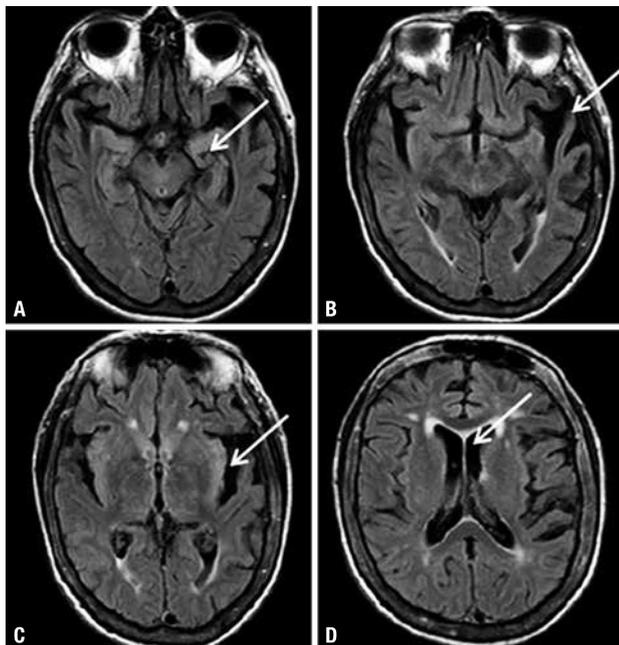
Axial FLAIR brain MRI Image reveals bilateral hippocampal reduction, predominantly to the left [A]; temporal lobe atrophy and extensive enlargement of Sylvian fissure, predominantly to the left [B and C]; Enlargement of CSF space [D].
